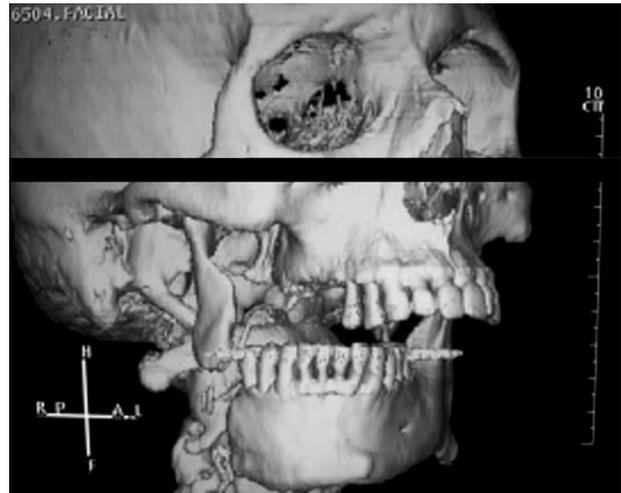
Three-dimensional computed tomographic scan of a right mandibular segmental defect after ablative surgery.
